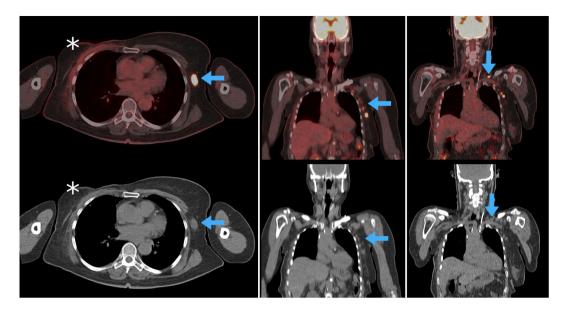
18F-FDG PET/CT axial and coronal fused images of reactive post-chemotherapy activity in the right breast (asterisk) and pathological contralateral axillary and retroclavicular lymphadenopathies (arrows).
